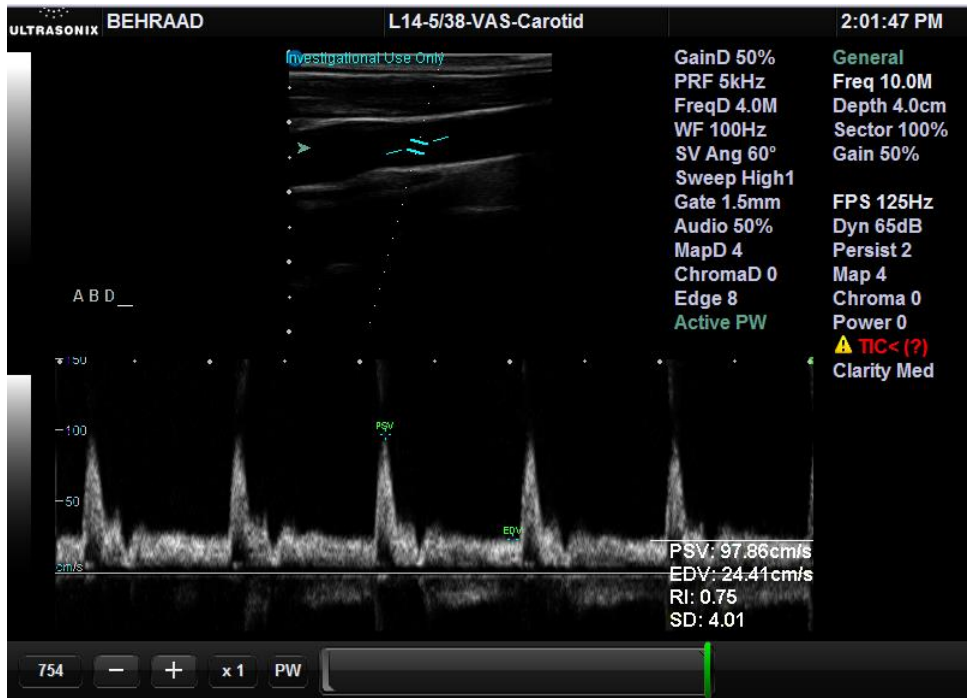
Ultrasound image of the left carotid artery with vibration applied to the descending aorta in the abdomen of the subject.
